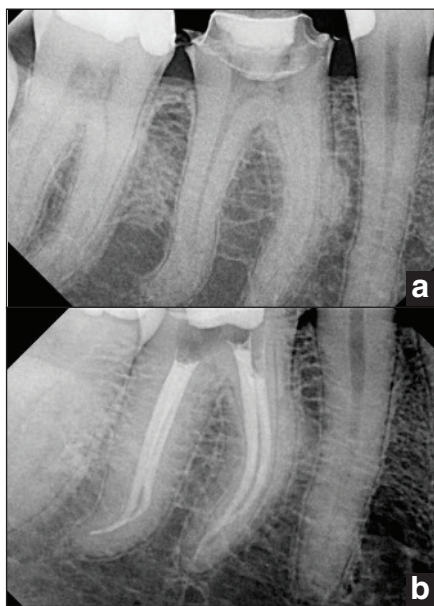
Pre- and post-op radiographs of a mandibular molar with .04 taper preparations and BC Sealer. Courtesy of Dr. Ali Nasseh, Boston.
